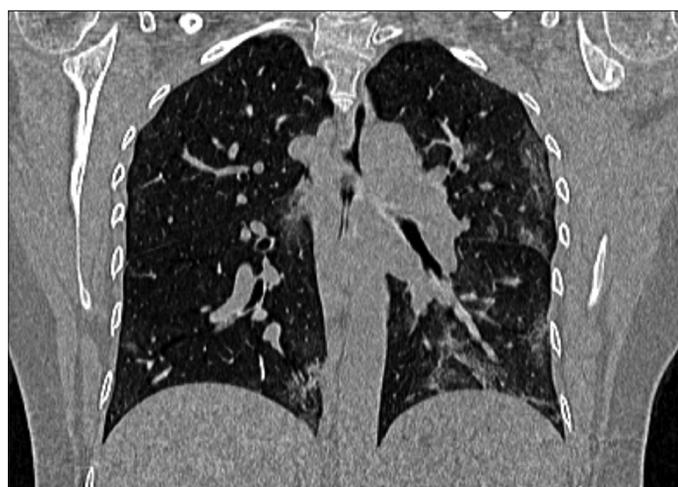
Chest computed tomography. A coronal section through the lung (lung window) shows bilateral multifocal peripheral and subpleural ground glass opacifications, which are more pronounced on the left side.
